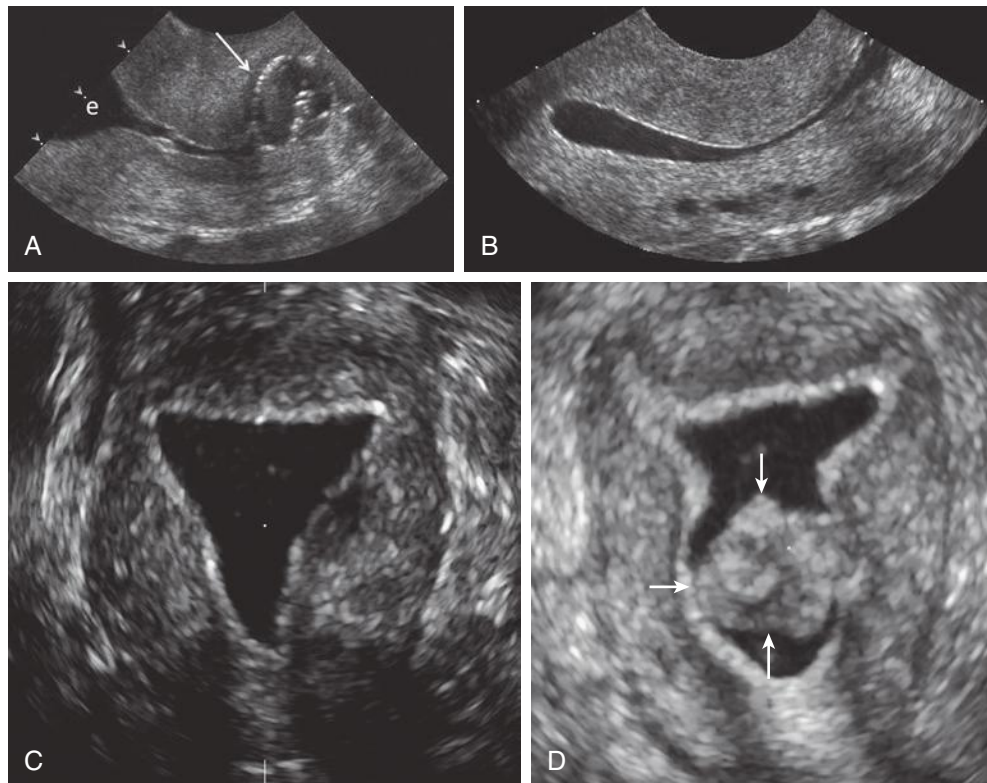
Saline-infused sonohysterogram. A, Transvaginal sagittal image of the cervix demonstrating the catheter balloon (*arrow*) positioned in the lower endocervical canal. Anechoic fluid is in the upper endocervical canal and lower endometrial cavity (*e*). B, Transvaginal sagittal image after saline infusion. The normal thin echogenic endometrium is well seen circumferentially. The endometrial cavity is filled with anechoic fluid. Note several small, round anechoic structures in a linear configuration in the posterior wall of the myometrium. These are the arcuate vessels and would fill in with color Doppler. C, A coronal three-dimensional reconstruction after saline infusion, demonstrating the normal regular, thin, echogenic endometrium without any intracavitary abnormalities. D, In comparison, a coronal three-dimensional reconstruction after saline infusion revealed a 100% intracavitary leiomyoma (*arrows*), separate from the thin, regular echogenic endometrium.
